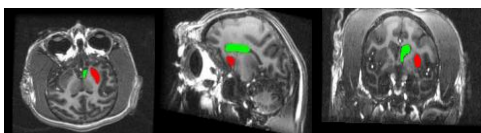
Location of the caudate (green) and putamen (red) in an MRI. The axial(left), sagittal (middle), and coronal (right)
